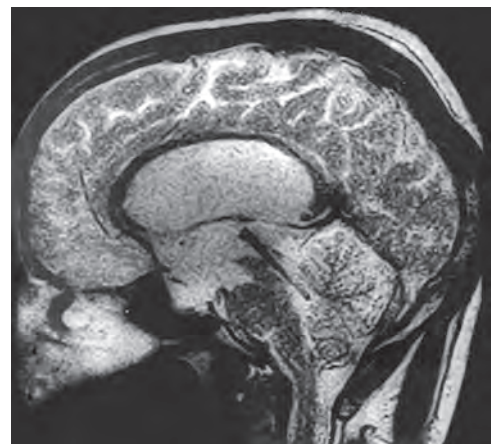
T2-weighted sagittal image of a patient with placement of aqueductal stent. Note: The wider shoulder of the stent preventing distal migration of the stent
